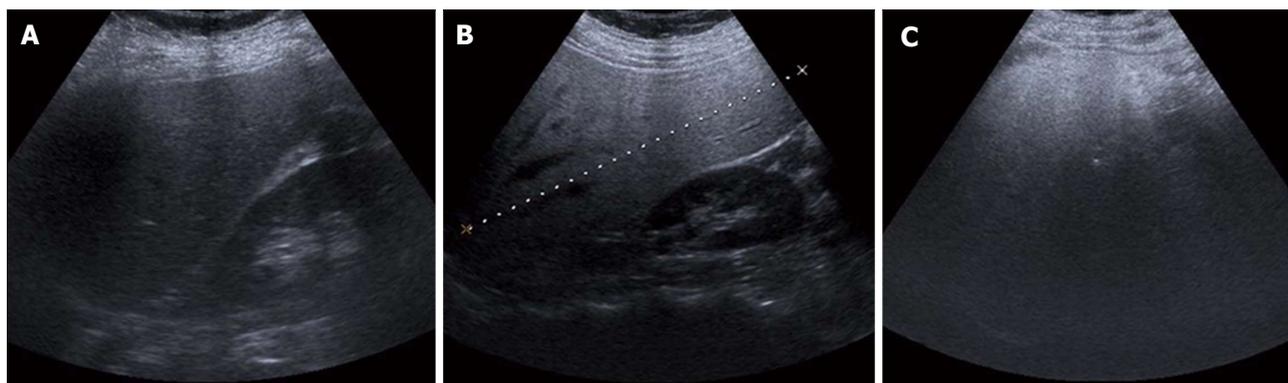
Ultrasonographic images show the hepatosteatosis stages. A: Grade 1: mild fatty liver; B: Grade 2: moderate fatty liver; C: Grade 3: severe fatty liver.
